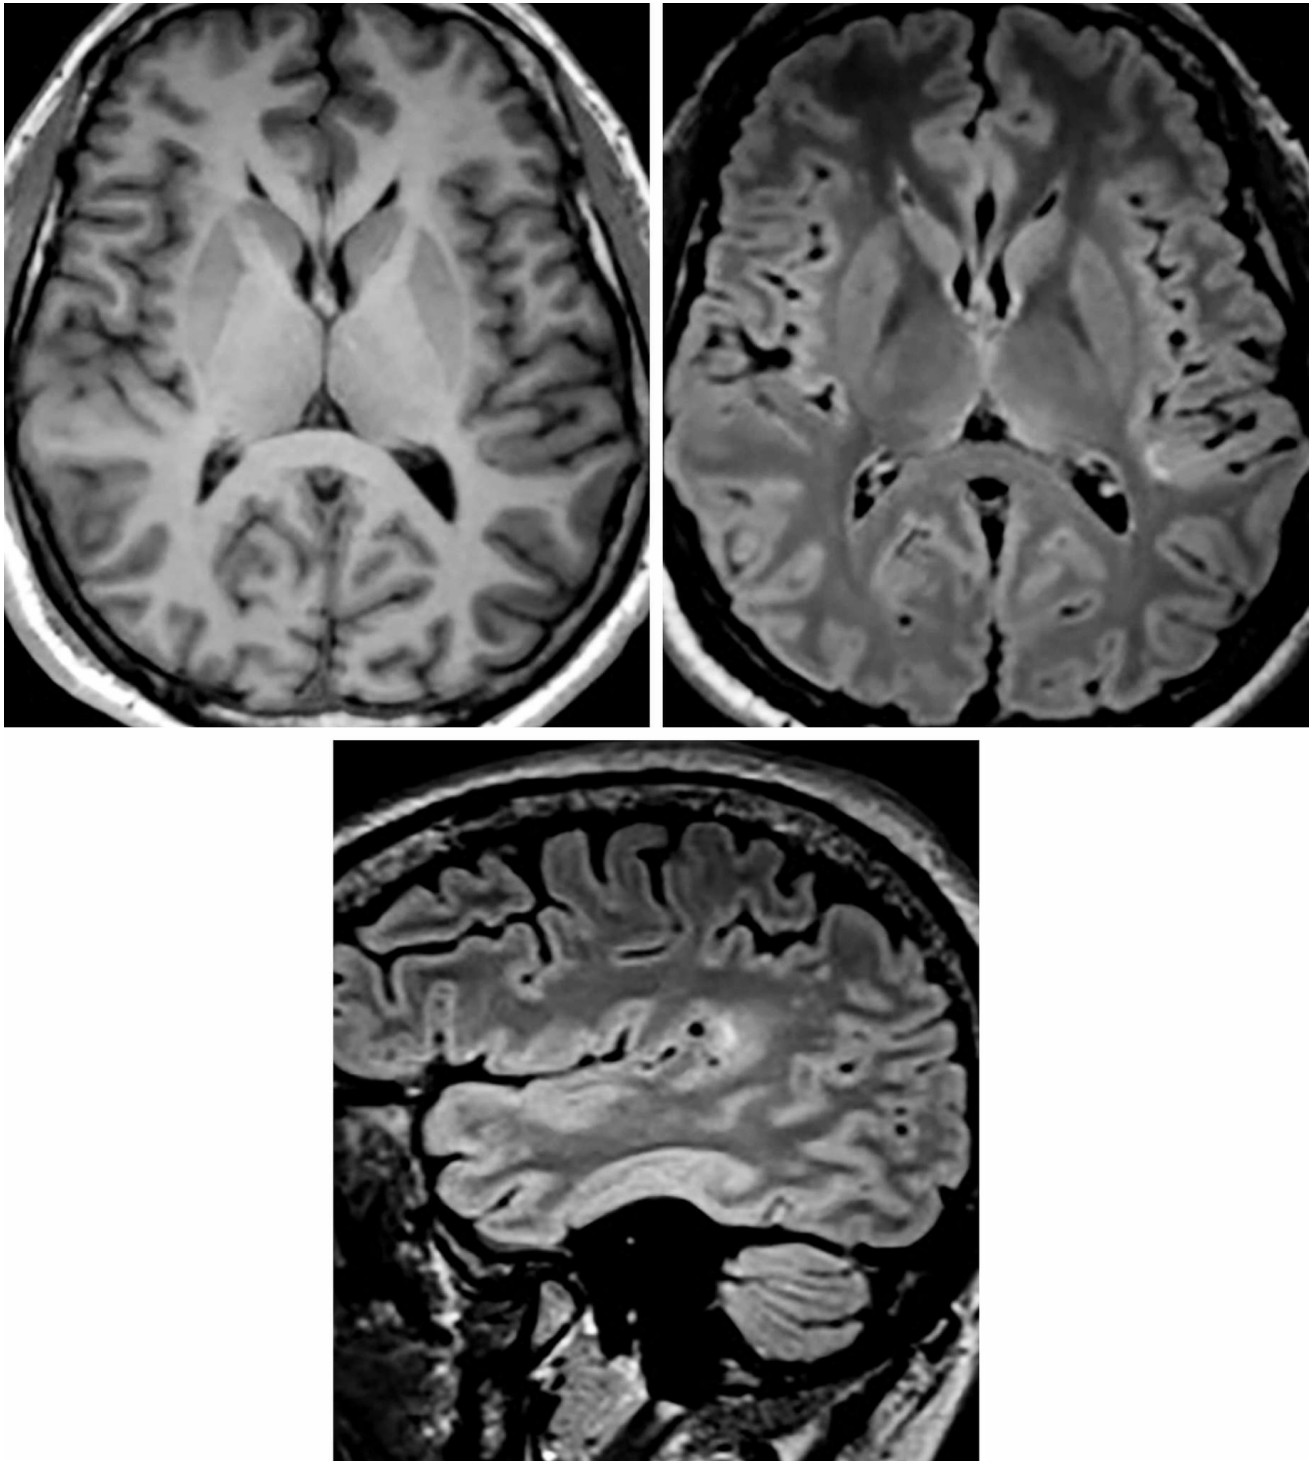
In this case, there is T1-isointense (top left), FLAIR-hyperintense (top right and bottom), nonenhancing signal within the left supramarginal and angular gyri subcortical white matter with overlying
